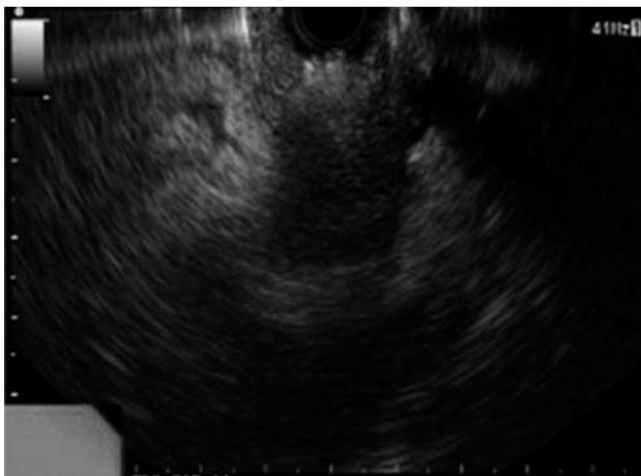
Endoscopic ultrasound image showing hypoechoic pancreatic mass with infiltration into duodenal walls.
